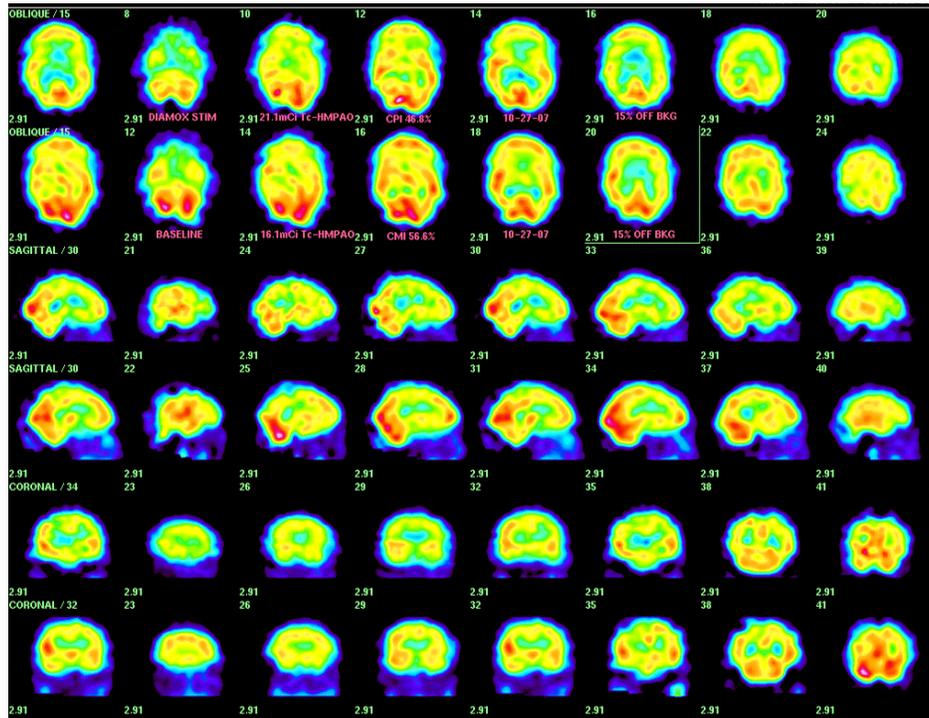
(above) SPECT images for a 71 year-old hypogonadal, type 2 diabetic man with hypothalamic hypoperfusion and stable renal insufficiency, GFR (46.4+-3) ml/min over 2 years, whose CR (46.8-56.6)% < 3 is also abnormal. Of a total of 4 pituitary patients with renal insufficiency, 75% (3/4) were exceptions to the usual observation of normal CR, these 3 together with 10 scans in 8 stroke patients (one of whom had pituitary apoplexy) accounting for 13/19 = 68.4% of the total number of such atypical cases.
